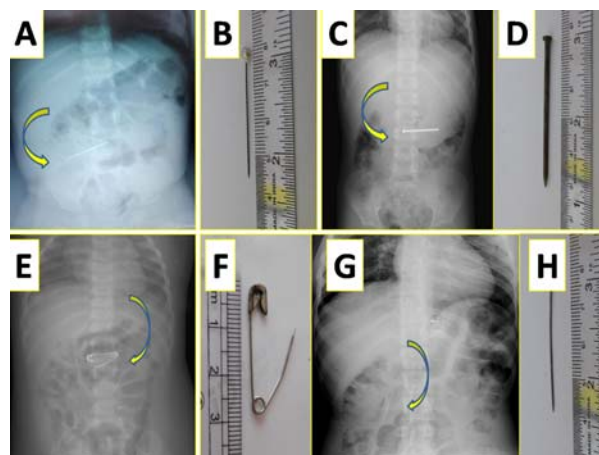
Ingested sharp metallic foreign bodies in four children, as seen in X-ray abdomen (A,C,E,G), and after spontaneous passage in stools (B,D,F,H).
